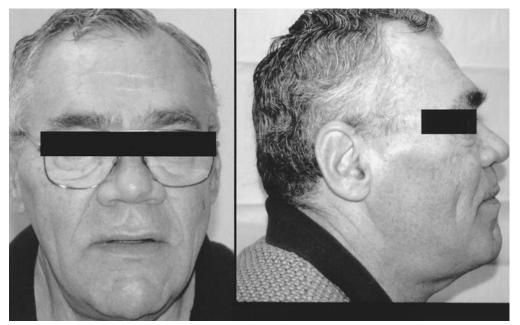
Photographs of a typical patient with multiple endocrine neoplasia type I and acromegaly owing to a growth hormone–secreting pituitary adenoma. Note the prominent brow and mandible. He also had gradual enlargement of his hands and feet. gland. The differential diagnosis begins with checking ACTH. Values < 10 pg/mL identify ACTH-independent Cushing's syndrome, in which case, a CT scan is indicated to evaluate the adrenal glands. If there is more than one lesion, then iodocholesterol scanning may be useful to identify functioning masses. Finally, the response to high-dose dexamethasone can differentiate the ACTH-dependent forms of Cushing's syndrome, either ectopic or pituitary.^{42–44}
